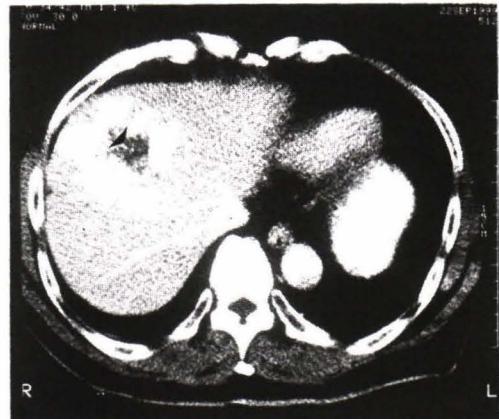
Lipiodol CT scan post TOCE of hepatic artery shows residual tumor (not opacified by Lipiodol) in right lobe liver (arrow).
